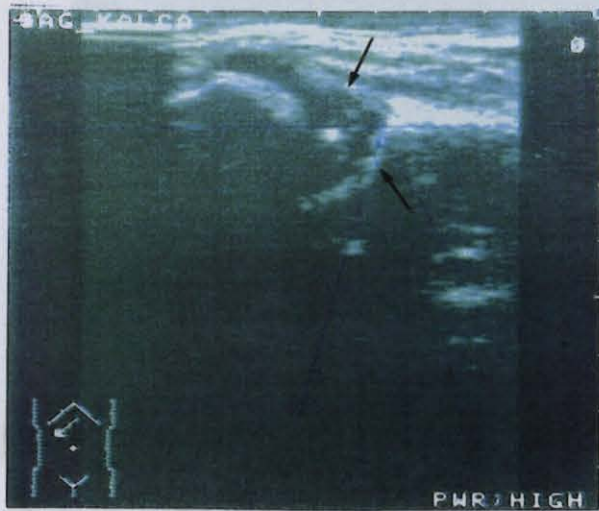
a) An X-Ray film ( A-P neutral) and b, c) ultrasound images from two different positions (b: axial, c: longitudinal) of a 3 months old patients with congenital hip dysplasia. 5.0 MHz linear transducer is used in ultrasound examination.
